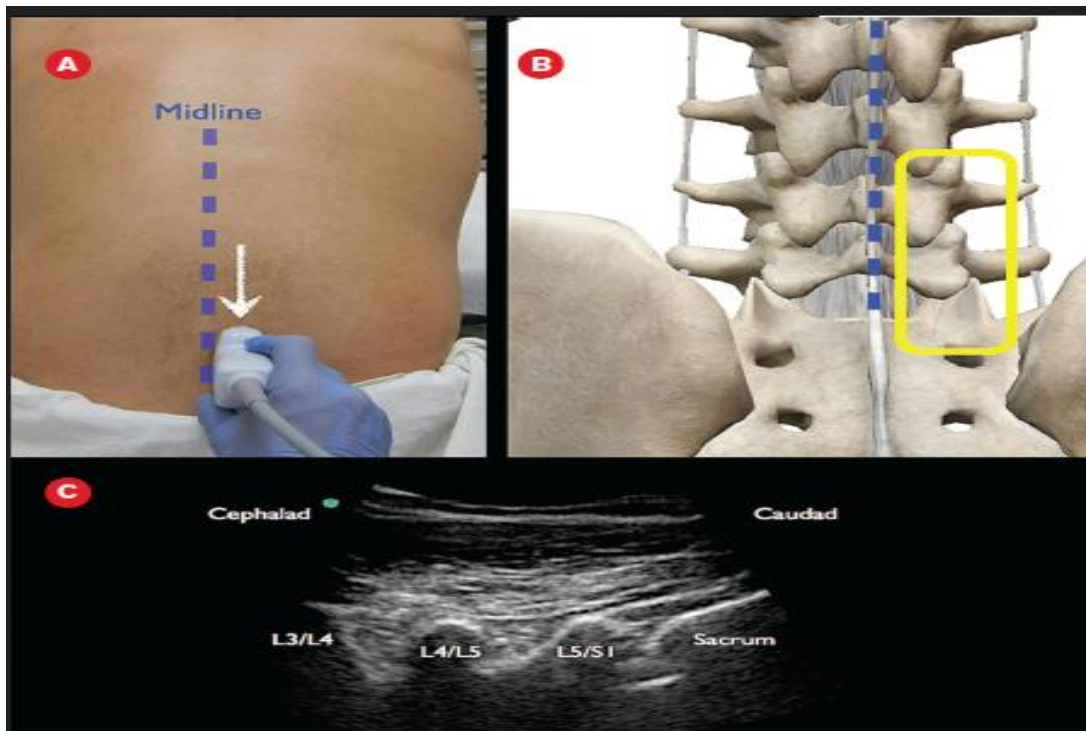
Ultrasound-Guided Localization of the L4-L5 Interspace
